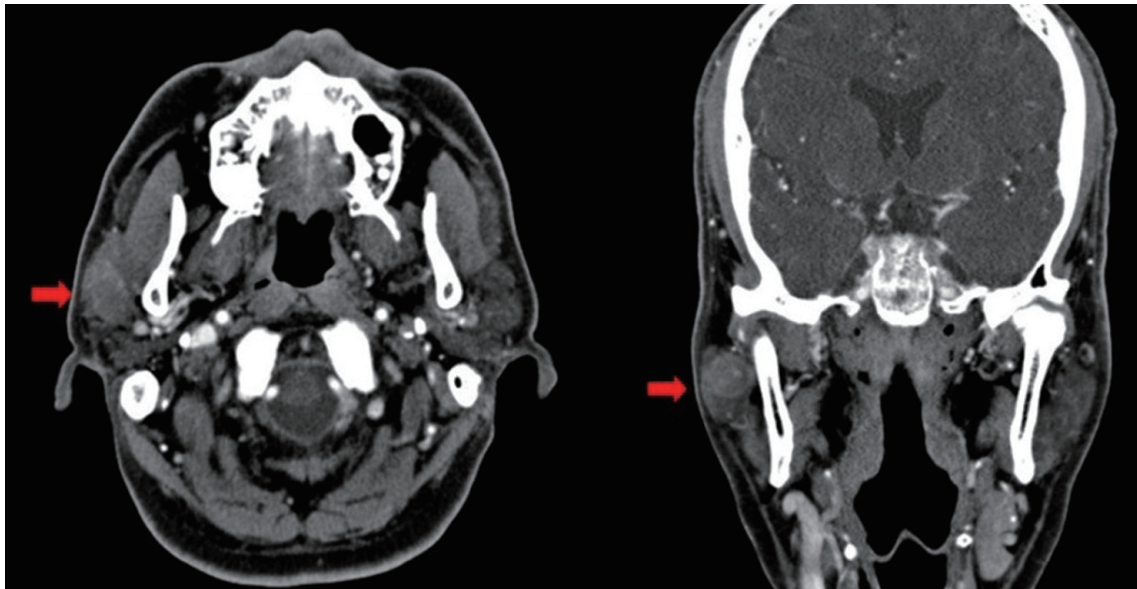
Preoperative facial computed tomography scan axial view and coronal view. The imaging shows a 3×1.5 cm sized intraparotid mass on the right cheek (red arrows). Calcification or hemorrhage was not found.
